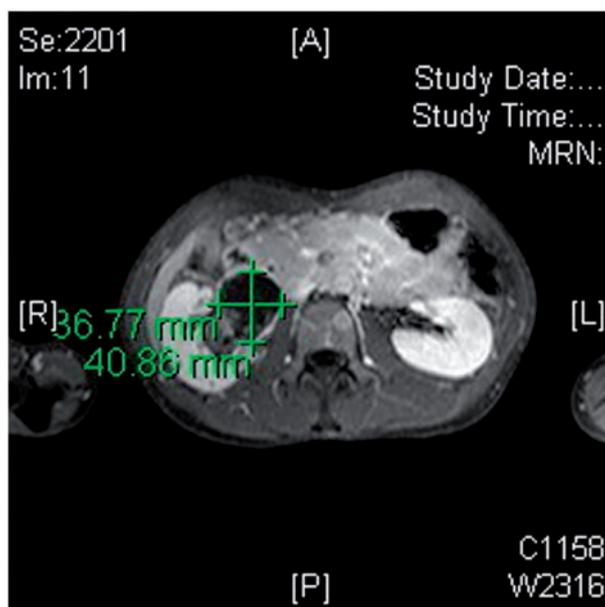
Surveillance MRI of the pelvis. This T1 slice with fat saturation and contrast performed 1 year after the initial presentation shows that the dominant AML measures 40.86 mm × 36.77 mm, a clear reduction in size. There is low signal fat within it, no evidence of blood products and 3–4 smaller AMLs.
